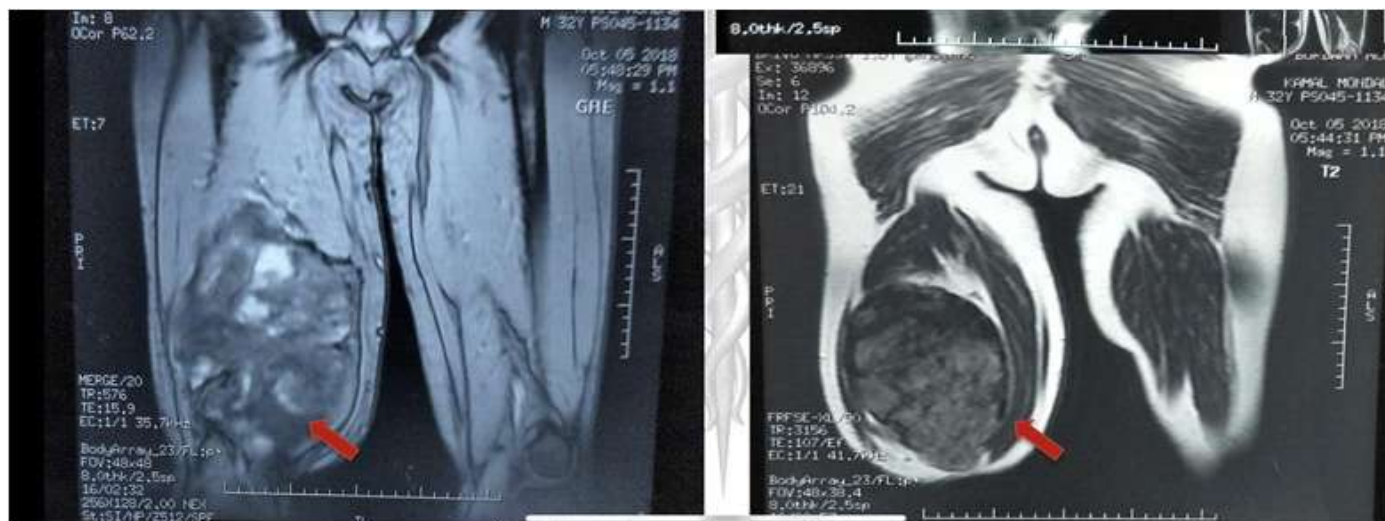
MRI Showing Space Occupying Lesion at Mid and Distal Part of Right Thigh
